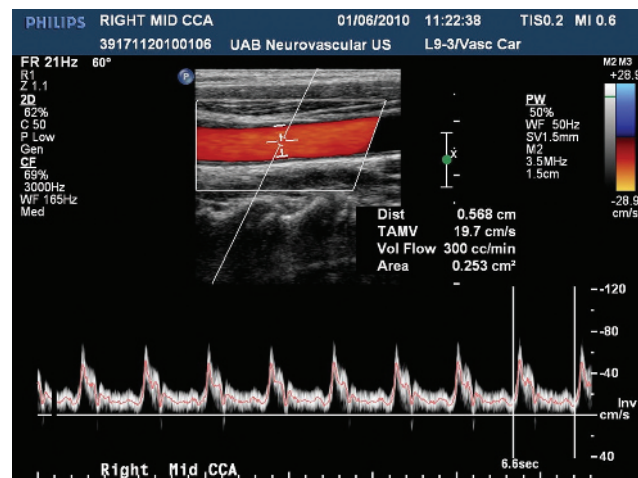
Placement of sample volume in the CCA using color flow image as a guide. A small (1.5 mm) gate is used for Doppler spectral measurement and a large (10 mm) gate is used for the flow volume measurements.
